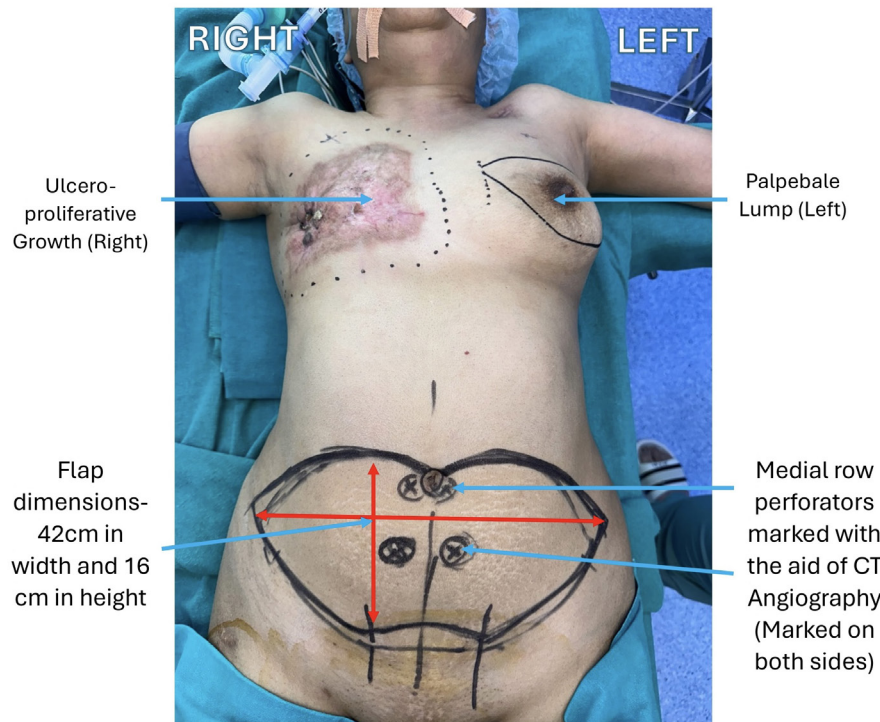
Preoperative markings for bilateral mastectomy and abdominal flap design. An ulceroproliferative lesion is visible on the right chest, and a palpable breast lump is outlined on the left. The lower abdomen is marked for harvest of a bipediced deep inferior epigastric perforator flap. Bilateral medial row perforators, identified using computed tomography angiography, are indicated to ensure adequate vascular supply. The planned flap measures 42 cm in width and 16 cm in height. These markings guide flap design, perforator dissection, and chest wall reconstruction.
